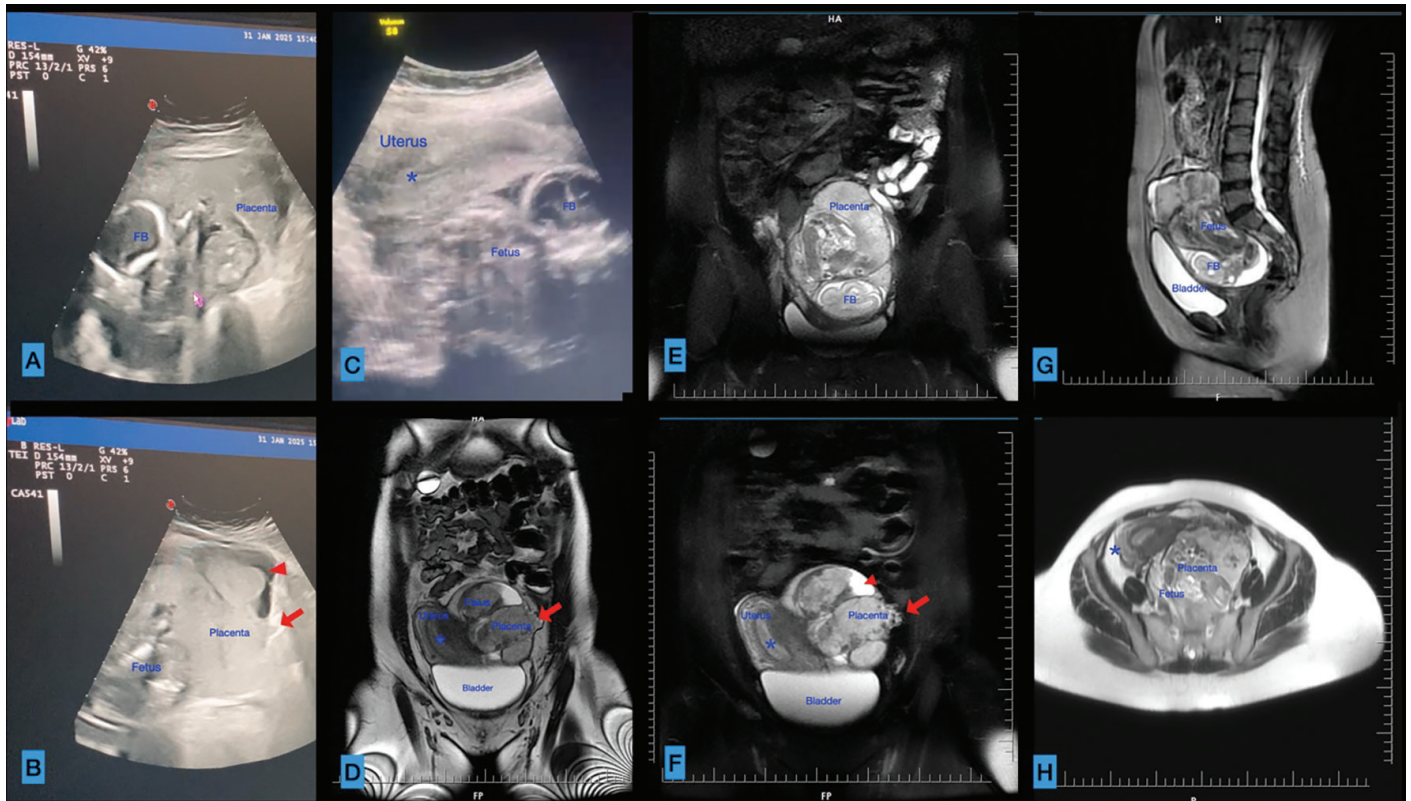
Ultrasonographic (A-C) and magnetic resonance (D-H) images of the patient at the time of diagnosis
